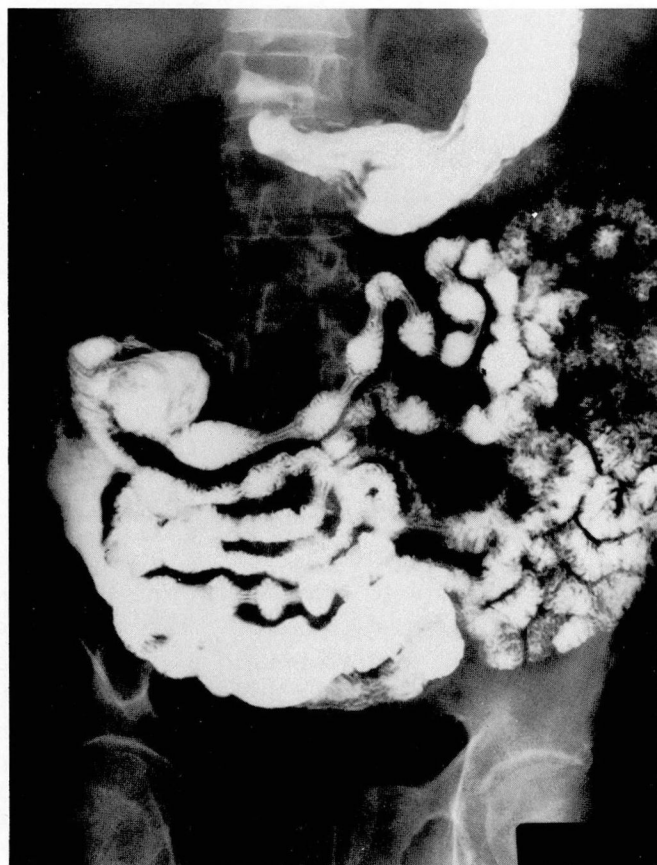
Case 2. Radiograph from small bowel series showing multiple areas of narrowing and irregularities of the distal ileum, with mild prestenotic dilatation.
